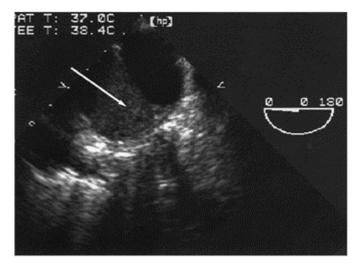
Transesophageal short-axis view of a dissection of the descending thoracic aorta. The false lumen (arrow) is thrombosed, showing a higher echodensity than the true lumen. Note dilation of the descending aorta.
